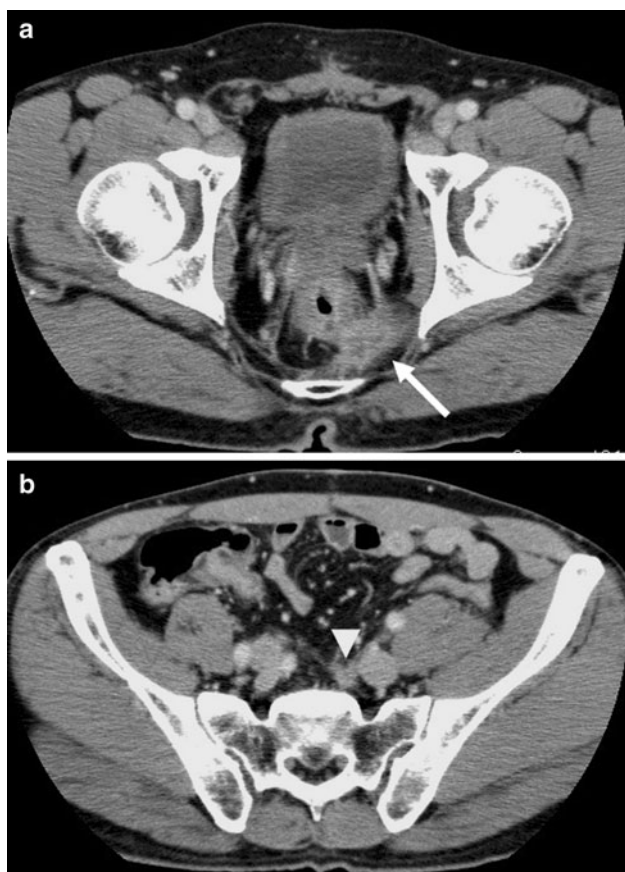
A pelvic CT scan showing a a local recurrence beneath the anastomosis (*white arrow*) and b a lymph node metastasis medial to the left common iliac vein (*white arrow head*)
